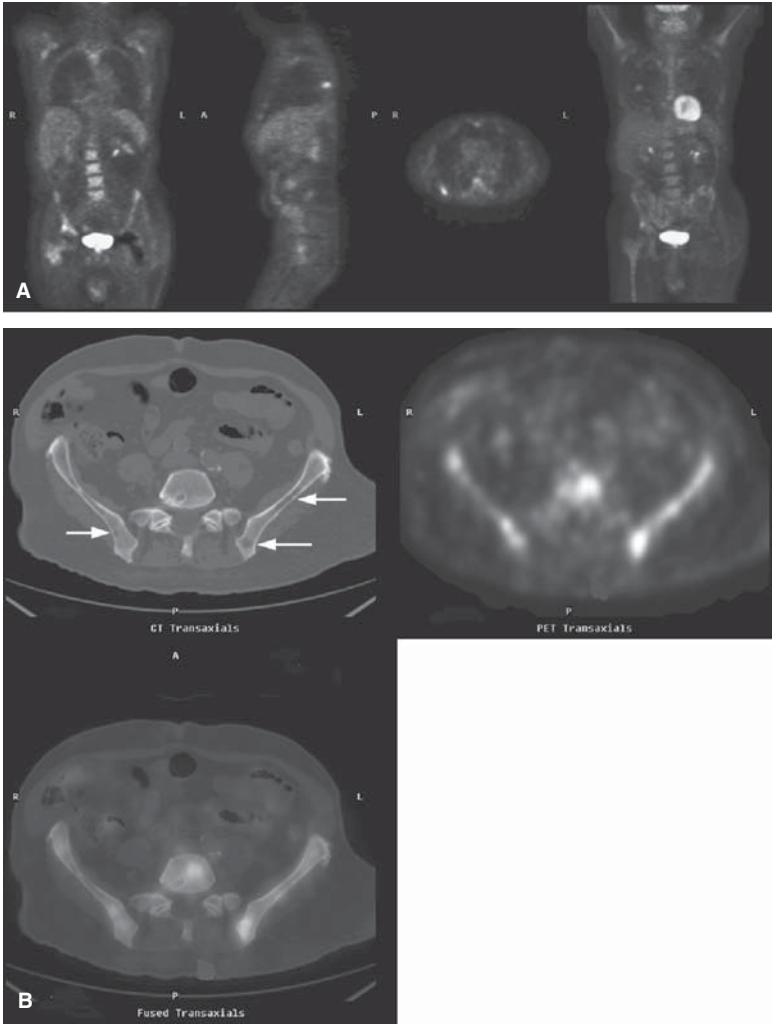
Skeletal metastatic disease in the setting of reactive marrow. (A) FDG-PET whole-body images demonstrate moderate diffuse FDG uptake in the bone marrow. This can be seen in patients undergoing chemotherapy, as a response to anemia, or following colony-stimulating factors. In this patient, however, there are foci of increased activity best seen in a right rib and within the pelvis consistent with skeletal metastatic disease. Also notice the photopenic left hip prosthesis on the coronal image. (B) Axial images demonstrate several lytic lesions in the bony pelvis (white arrows) with corresponding hypermetabolism. Notice the diffuse, less intense FDG uptake elsewhere in bones likely represents physiologic marrow recruitment changes.
